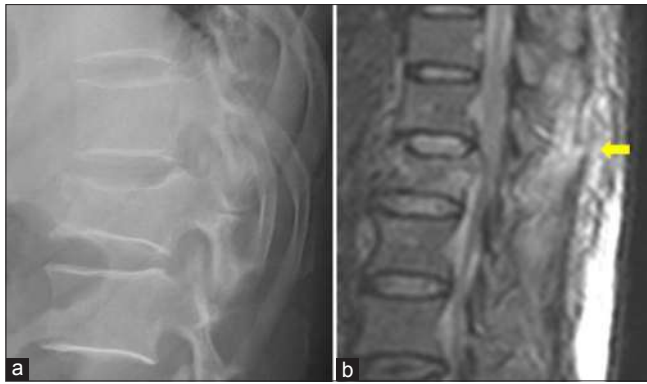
(a) Lateral radiograph of thoracolumbar spine showing a burst fracture of L1 vertebral body. (b) Sagittal magnetic resonance image shows a hyper intense signal of the posterior ligamentous complex (yellow arrow) indicating injury, which is not detected in the radiograph
